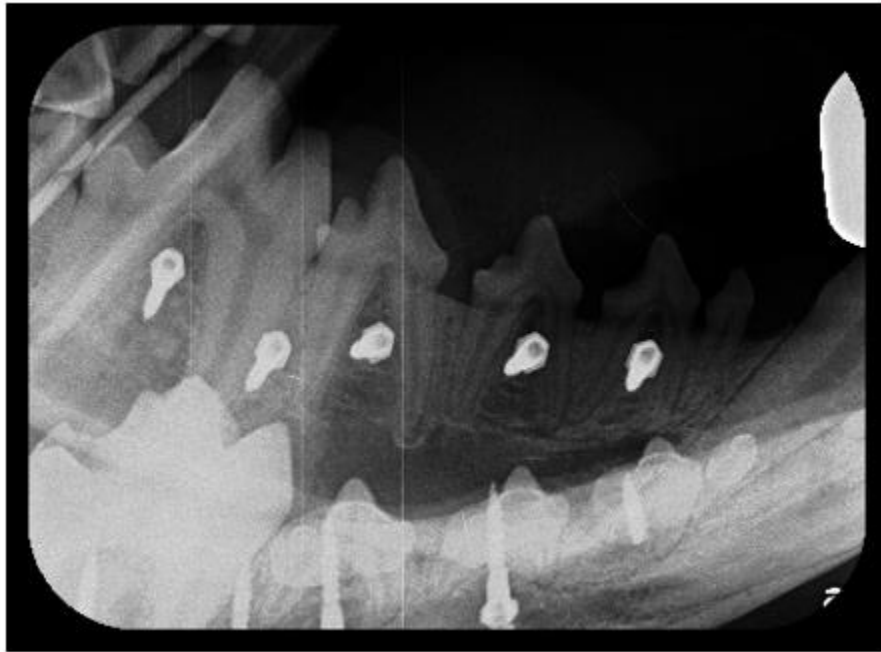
Initial MSI Placement Radiographs.
